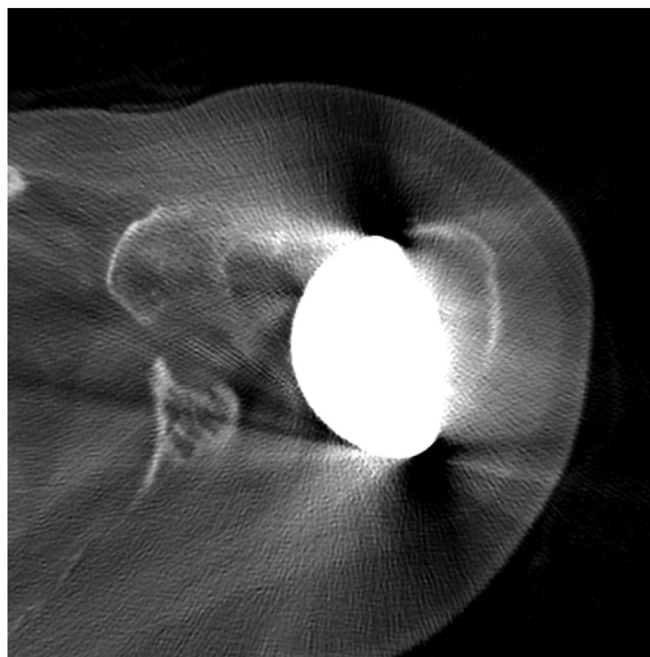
Prerevision axial CT slice of the left shoulder demonstrating severe glenoid bone loss. CT, computed tomography.
